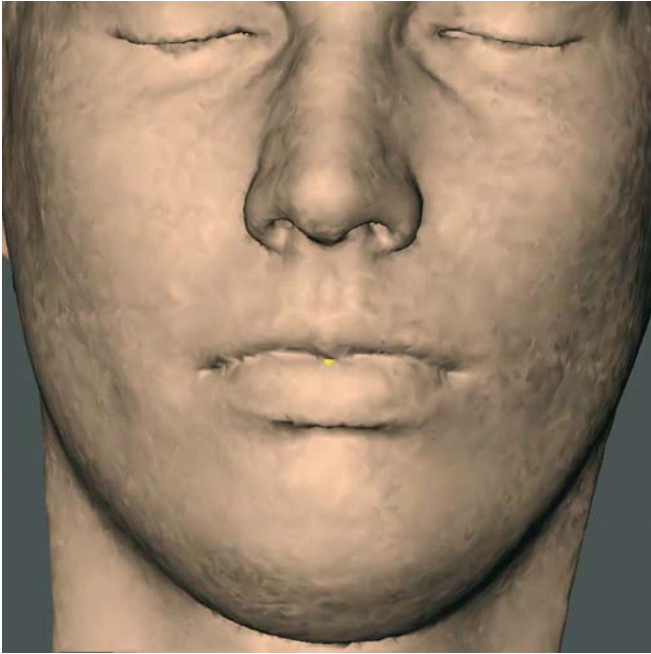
Stomion. Frontal view (3-D CT, patient K.C.)
